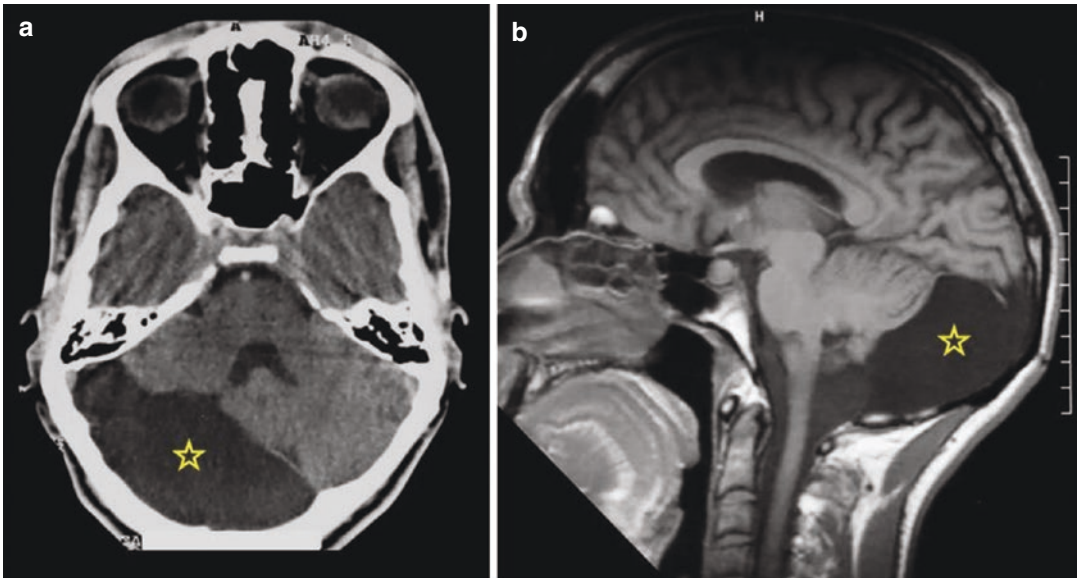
Cerebellar AC. Axial CT scan (a), axial T1-weighted MRI (b), axial FLAIR image (c), and axial T1-weighted image following gadolinium administration (d)
